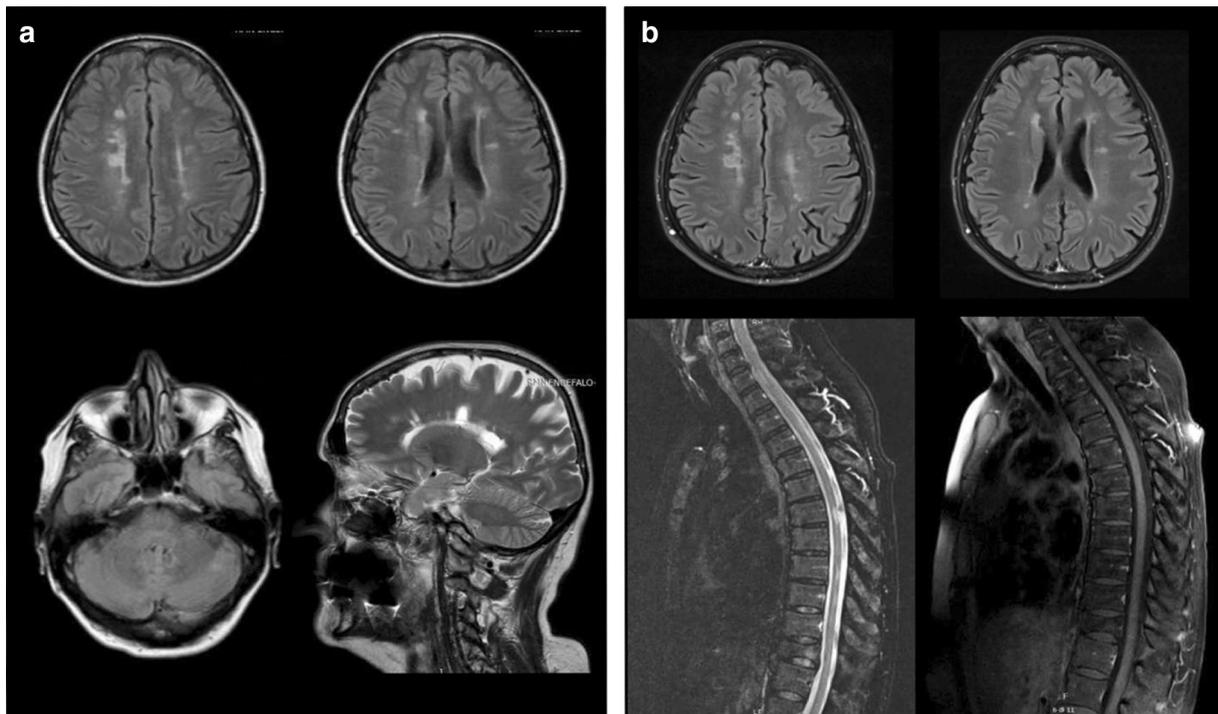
a MRI performed during a routine follow-up for cancer staging (August 2017). Multiple T2 periventricular and infratentorial demyelinating lesions in the brain and in the corpus callosum are visible. b
